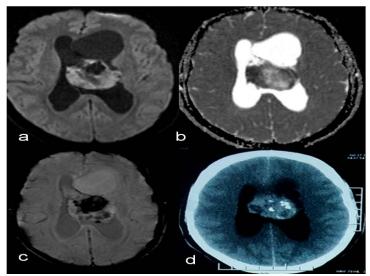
(a, b, c, d): (a)DWI and (b)ADC MR Axial Images-solid appearing areas of mass showing diffusion restriction suggestive of high cellularity.(c)SWI shows marked blooming in mass suggesting hemorrhage/calcification.(d) CT Axial Image confirming tumoral amorphous calcification
